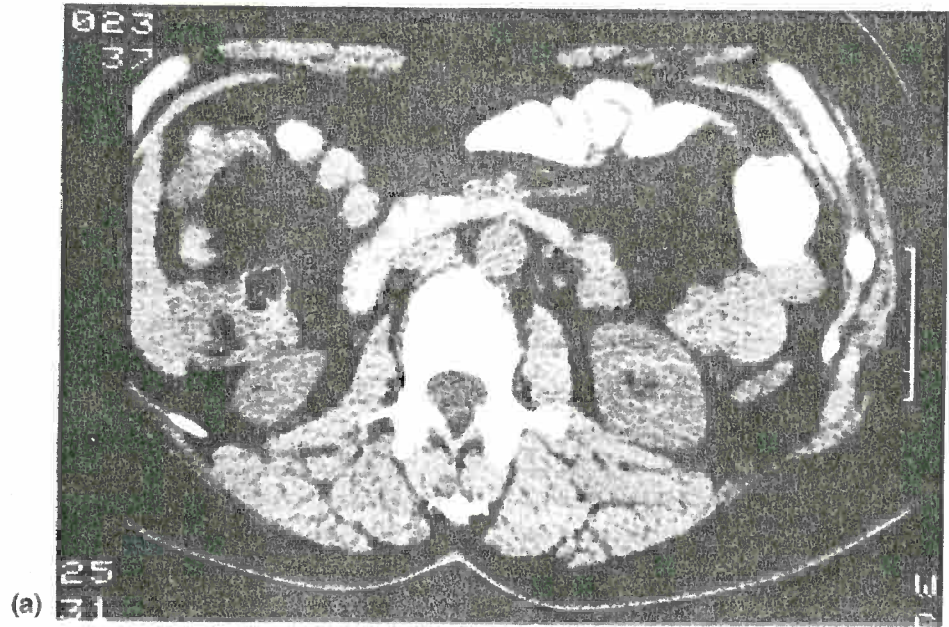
CT images of the lower pole of the right kidney (4 mm thick, contiguous slices). Precontrast scan (a): normal parenchymal densitometry, no cists. Post-contrast scan (b) reveals a small, round shape, solid hypodense mass.
